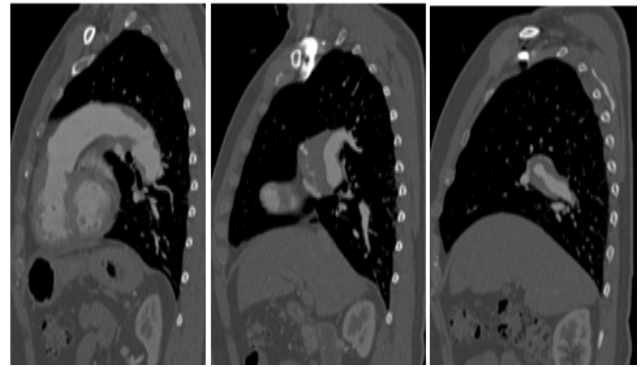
CT Chest with IV contrast sagittal Images in bone window depicts calcification better. Diffuse irregular eccentric thickening of right main pulmonary artery which extends to major lower lobar (inferior) pulmonary arteries, with luminal narrowing of right main pulmonary artery with patent lumen. No acute thrombosis. Peripheral calcification on right side.
